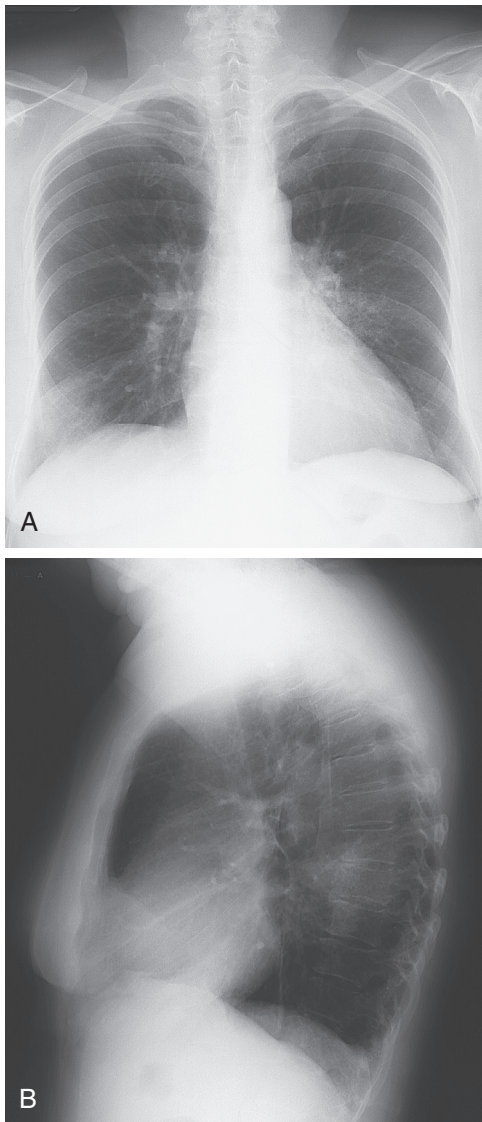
■ Posteroanterior (A) and lateral (B) chest radiographs demonstrating segmental pneumonia involving the superior segment of the left lower lobe.
